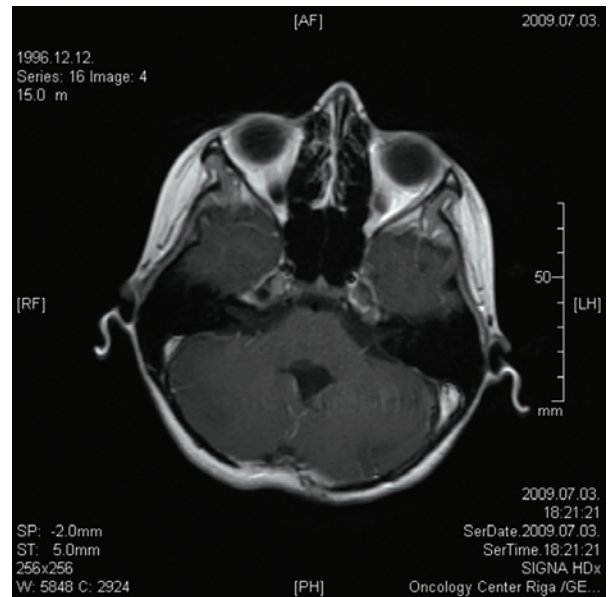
Post-operative control MRI scan. Status after subtotal resection. Minimal residual tumour tissue without mass effect and disturbance to CSF circulation
